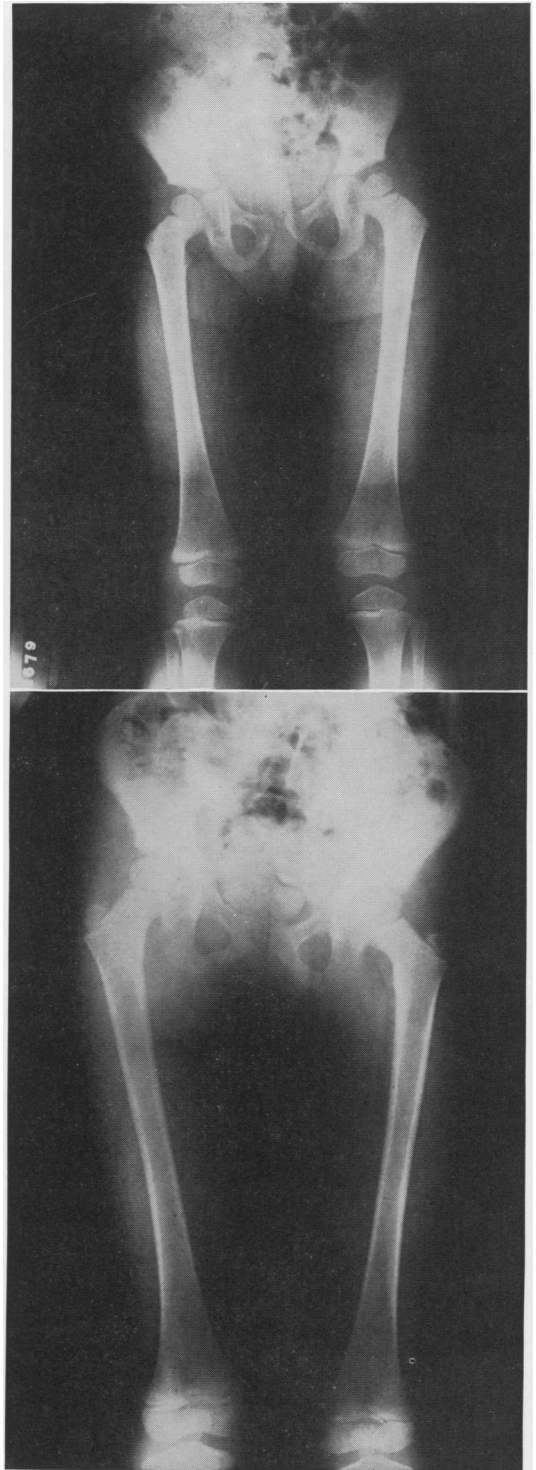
Roentgenograms of the pelvis and femurs of the patient at 2 years and at 5 years of age. Roentgenograms were taken at a focal film distance of 7 feet.
